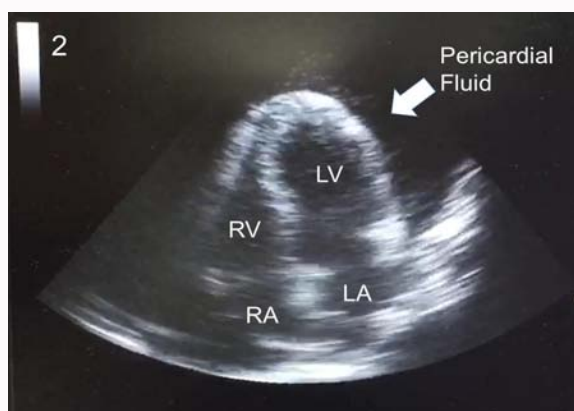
Echocardiogram showed massive pericardial effusion with right atrium and right ventricle collapsed. LV: Left Ventricle; LA: Left Atrium; RV: Right Ventricle; RA: Right Atrium
